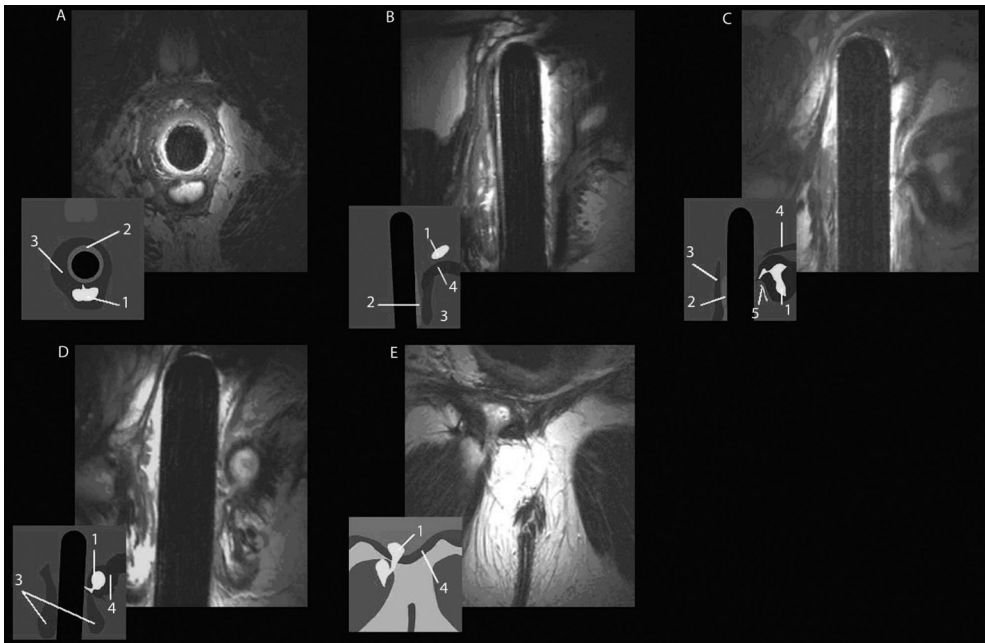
MR images of abscesses. A, Intersphincteric abscess. B, Supralevator abscess. C, Infralevator abscess. D, Intralevator abscess. E, Translevator abscess. 1 = abscess; 2 = internal anal sphincter; 3 = external anal sphincter; 4 = levator muscle; 5 = fistulous tract.
